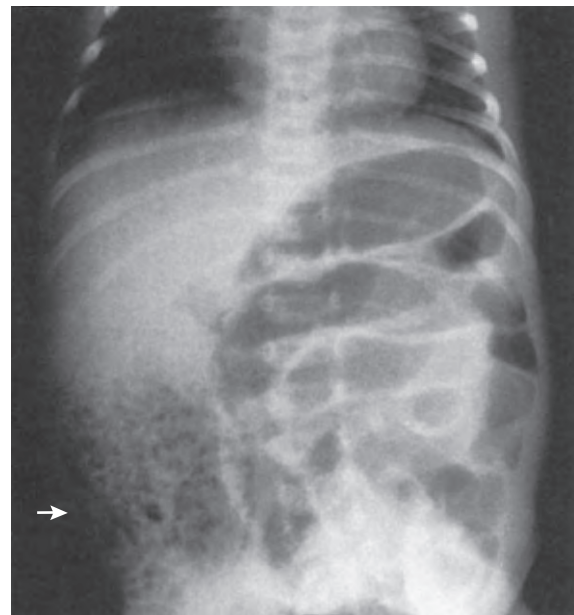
Plain abdominal radiograph of meconium ileus with distended loops of bowel and a mass of meconium (arrow) with a "ground glass" appearance from mixed air and stool. (From Ashcraft KW, Holder TM [eds]: Pediatric Surgery. Philadelphia, WB Saunders, 1999.)
